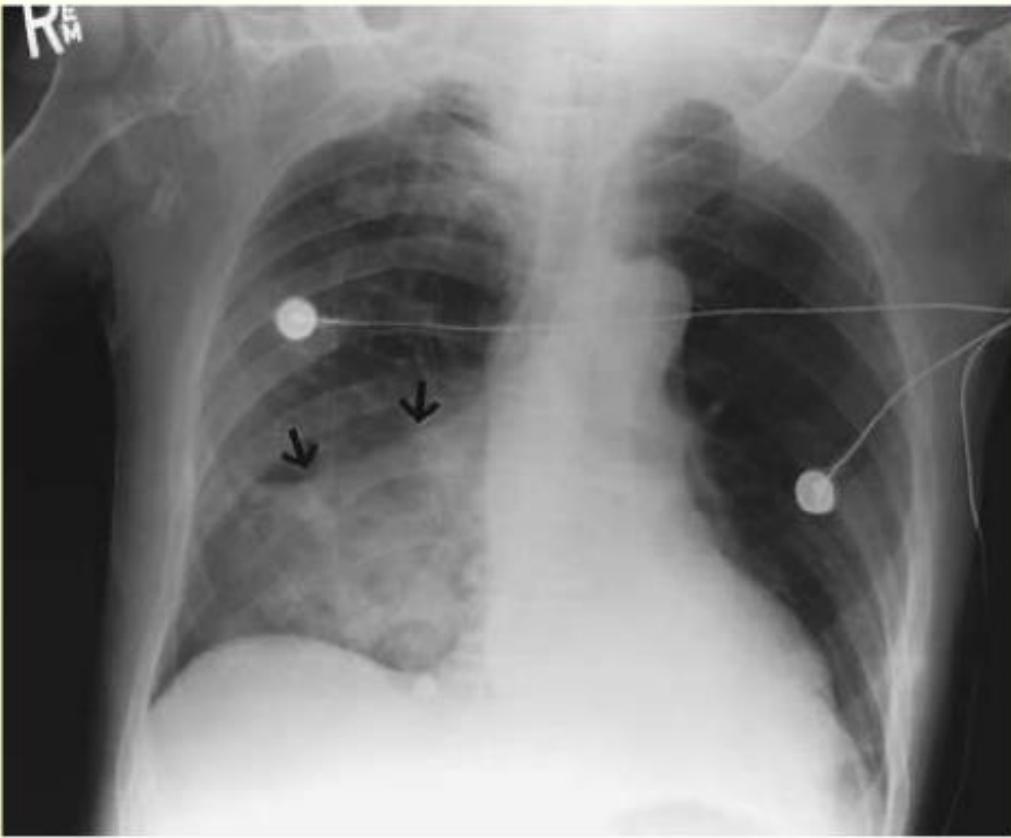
Anteroposterior Radiograph of the Chest, Showing Air-Space Consolidation (Arrows) in the Right Lower Lobe in a Patient Who Had Recently Had a Thrombotic Stroke.
